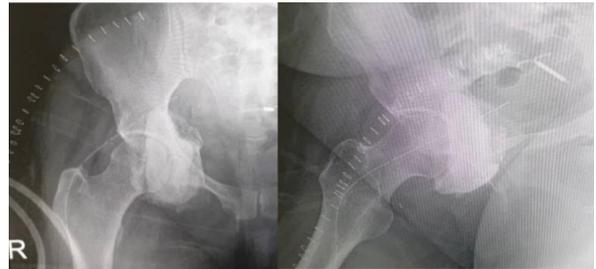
Anteroposterior view of right hip plain radiograph post extensive curettage and acetabular cementoplasty
